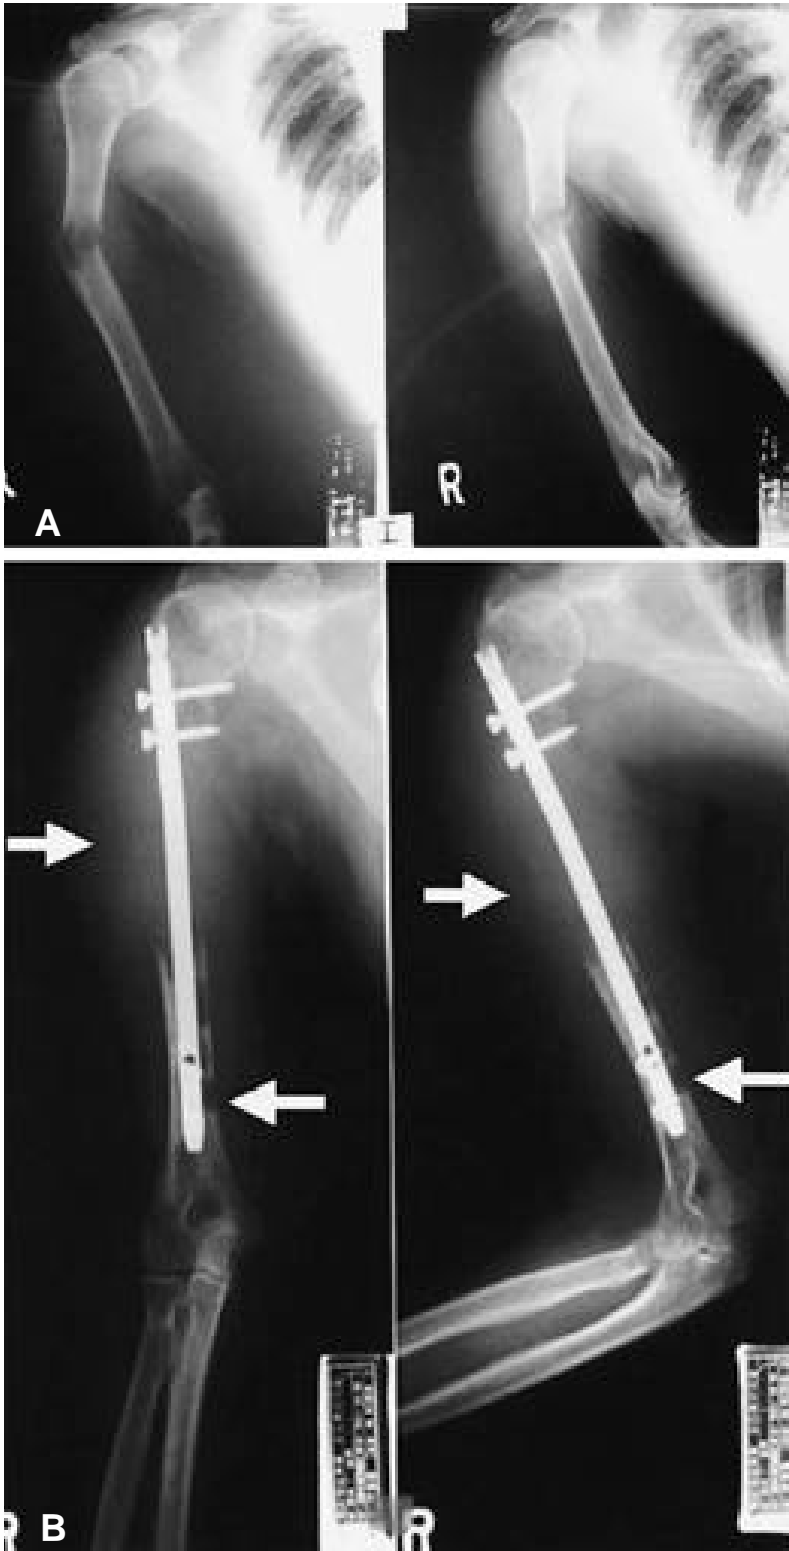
A. Plain radiograph shows ill-defined geographic destruction with pathologic fracture of diaphysis of humerus. The patient was 63-years old lady with lung cancer for 8 months. B. Plain radiograph demonstrates significant tumor progression with loss of fixation failure at 3 months after surgery. The final result was poor both in pain relief and function recovery.
